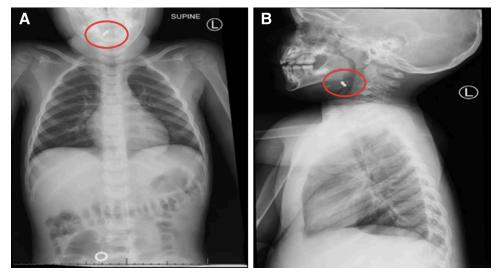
A) AP radiograph from the nose to the abdomen, revealing the same ring of 12 magnetic beads in the RLQ, as well as three beads in the upper aerodigestive tract; B) Lateral view of the neck and chest, confirming the location of at least three beads in the hypopharynx. RLQ = right lower quadrant.
